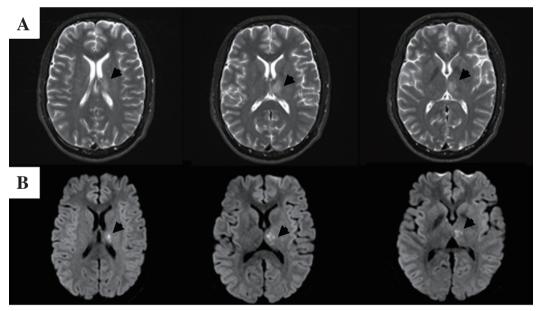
Brain MRI sequences with T2-weighted and fluid-attenuated inversion recovery (A) and DWI(B). The left medial thalamus lesion was enhanced on both views labeled by arrows.
